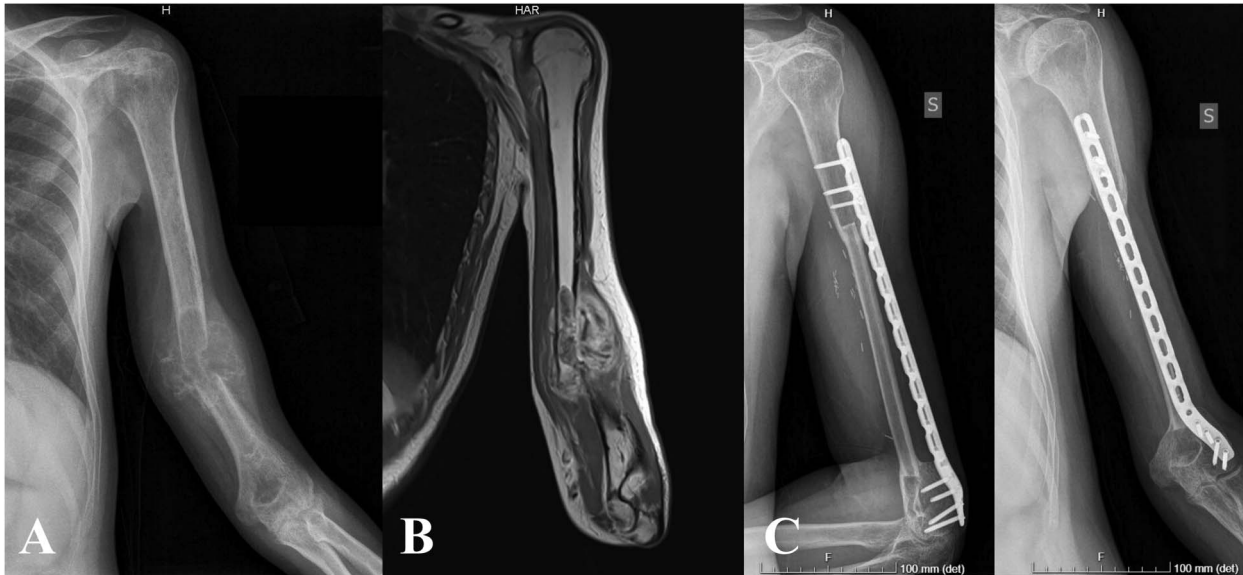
(A) This is a radiograph of a 29-year-old man with a pathologic fracture of the humeral diaphysis because of high-grade osteosarcoma that healed after preoperative chemotherapy. (B) This coronal T1-weighted MR image with contrast shows an aggressive bony lesion with an extrasosseous mass, without involvement of the proximal and distal part of the humerus. (C) This radiograph taken 37 months after intercalary resection and reconstruction with a VFG and a bridging plate shows union of the fibula with slight hypertrophy owing to stress shielding induced by the bridging plate. The plate is fixed on the lateral column of the distal humerus, taking advantage of the scarce residual bone stock.
